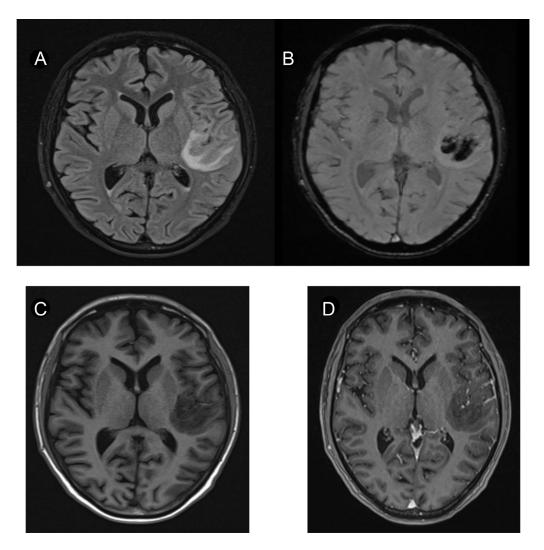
Initial MRI brain. (A) T2 FLAIR shows an area of high T2 and FLAIR signal at the subcortical white matter of the left posterior insula and temporoparietal regions; consistent with vasogenic edema. (B) The same area shows dark SWI blooming consistent with intraparenchymal hemorrhage. (C) T1 weighted image pre contrast. (D) T1 weighted image post contrast shows overlying leptomeningeal enhancement and engorged vessels within the pathological area.
